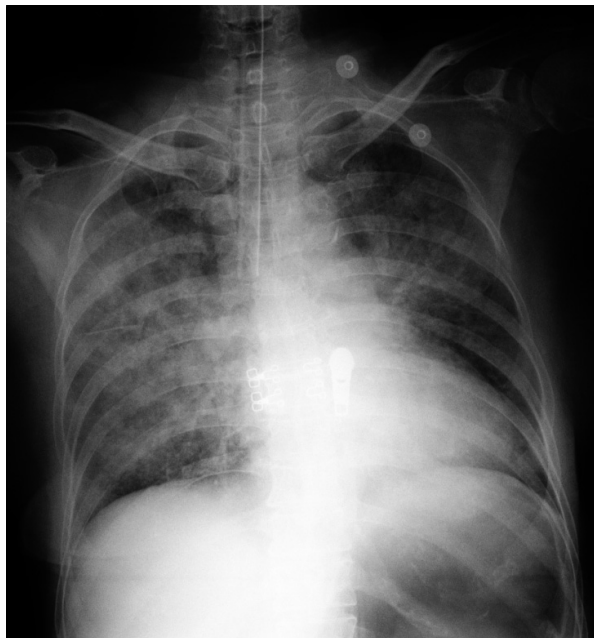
Chest radiograph (anteroposterior view) revealing bilateral perihilar alveolar infiltrates and cardiomegaly, suggestive of pulmonary edema (Note: the intubation was too deep, and was drawn into an adequate position after this chest X-ray).
